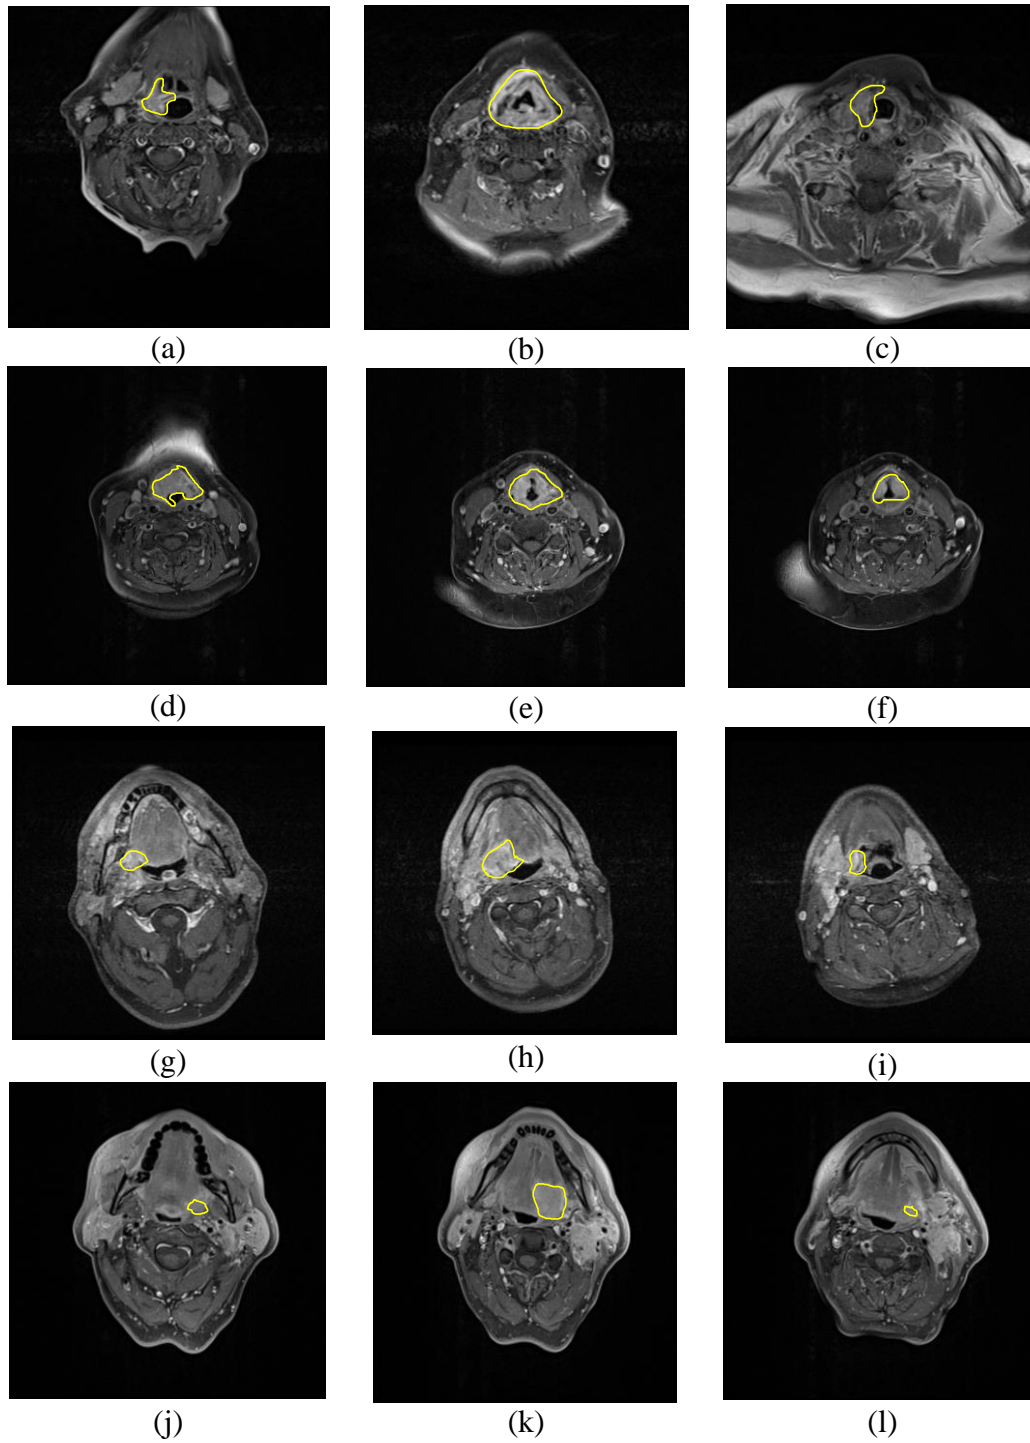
Examples of T1 axial MRI slices with HNC marked by yellow. (a-c) are slices from top to bottom order of first patient. (d-f) are from second patient. (g-i) are from third patient. (j-l) are from fourth patient.
